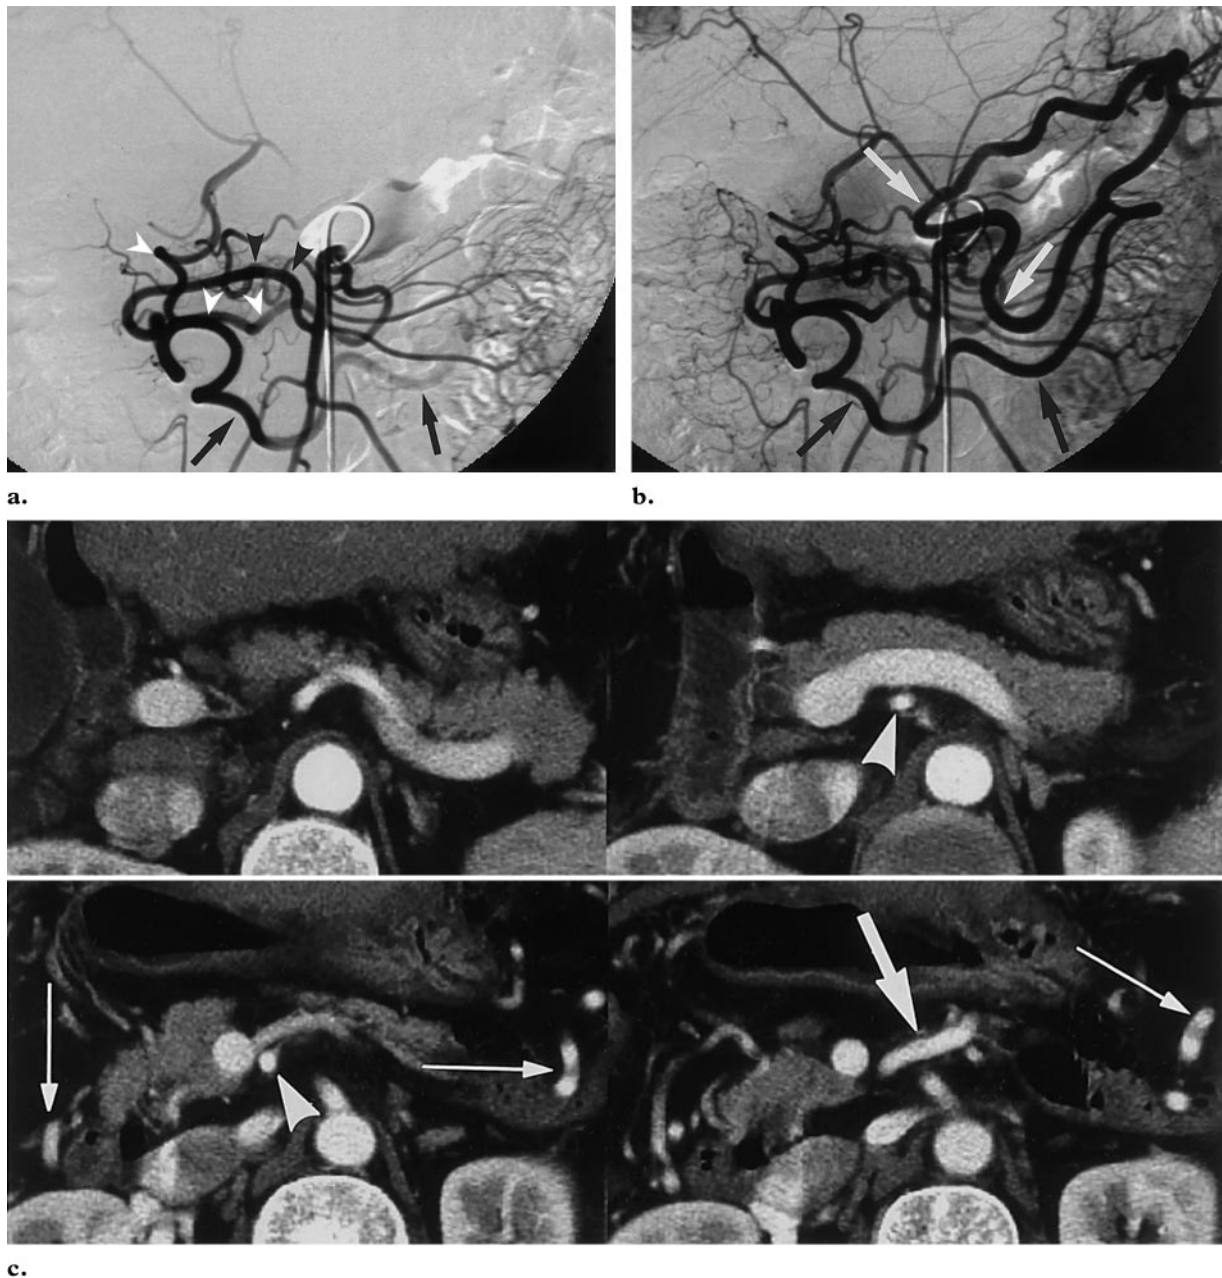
Longitudinal pathway via the dorsal pancreatic artery. (a) Early arterial-phase superior mesenteric arteriogram shows a large, hypertrophic marginal artery of the colon (arrows) that arises from the right colic artery (black arrowheads). Retrograde contrast material filling of the hepatic artery via a pancreaticoduodenal arcade (white arrowheads) is also noted. (b) Later arterial-phase arteriogram reveals that the hypertrophic marginal artery (black arrows) is continuous with the middle colic artery (white arrows), which arises from a dorsal pancreatic artery of splenic artery origin. (c) Serial spiral CT scans show a large middle colic artery (thick arrow) that arises from the dorsal pancreatic artery (arrowheads). Note the hypertrophic marginal arteries of the colon (thin arrows).
